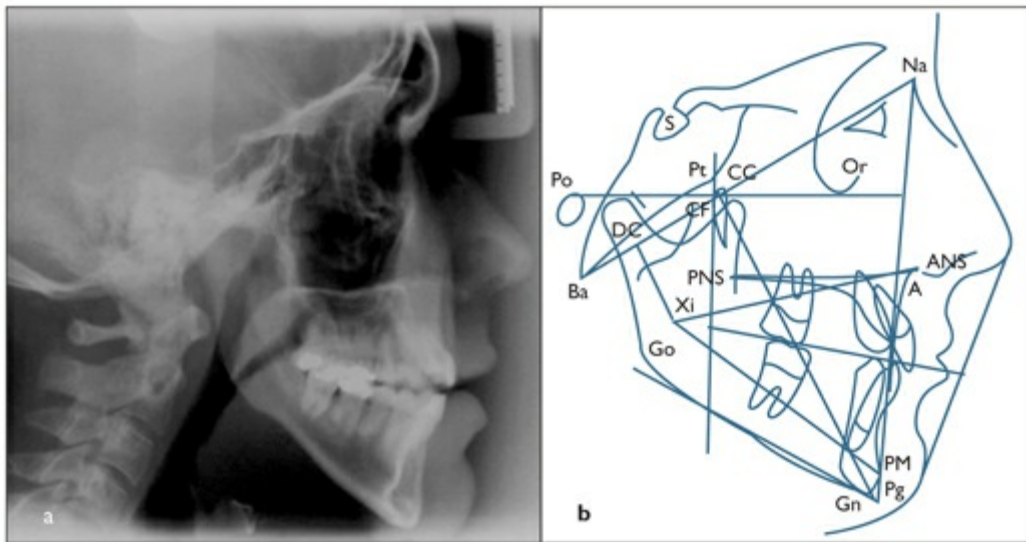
(a) Lateral radiograph of the head and neck. (b) Initial cephalometric analysis. (Na) Nasion: anterior limit of the nasofrontal suture; (ANS) anterior nasal spine; (point A) deepest point of the curve of the maxilla between the anterior nasal spine and the dental alveolus; (PM) suprapogonion (protuberance menti): where the curvature of anterior border of the symphysis changes from concave to convex; (Pg) pogonion: most anterior point on the midsagittal symphysis; (Gn) gnathion: intersection of the tangent to the most inferior point on the inferior border of the symphysis and the most inferior point of the gonial region and the line Na-Pg; (Go) gonion: intersection of the line connecting the most distal aspect of the condyle to the distal border of the ramus (ramus plane) and the line at the base of the mandible (mandibular plane); (Po) porion: most superior point of the external auditory meatus; (Ba) basion: most inferior posterior point of the occipital bone at the anterior margin of the occipital foramen; (point Pt) pterygoid: intersection of the inferior border of the foramen rotundum with the posterior wall of the pterygomaxillary fissure; (point CF) center of face: intersection of the line Po-Or and a perpendicular line through Pt; (point CC) center of cranium: intersection of the two lines Ba-Na and Pt-Gn; (point DC) center of the neck of the condyle; (point Xi) geometric center of the ramus; (PNS) posterior nasal spine; (Or) orbitale: lowest point on the external border of the orbital cavity; (S) sella.
